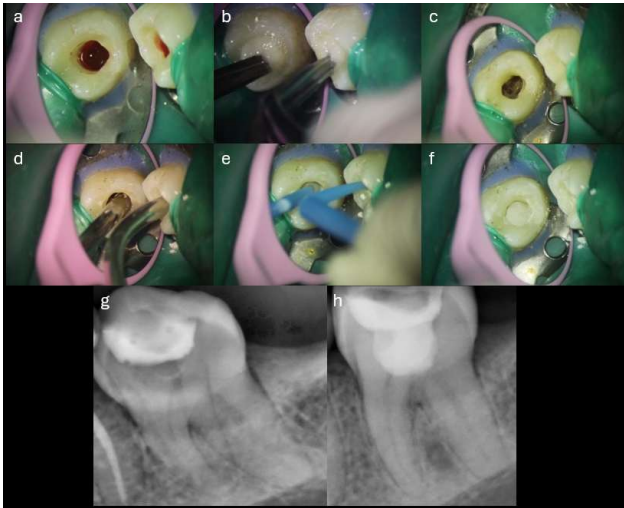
(A) Pulp exposure and bleeding, (B) Hemostasis, w/ 3% NaOCl, (C) Confirmation of hemostasis and clean surface, (D) Placement of MTA using MAP VPT, (E) Gently condensation, (F) Confirmation of adequate placement, (G) Preoperative radiograph, (H) 6-month follow-up radiography
